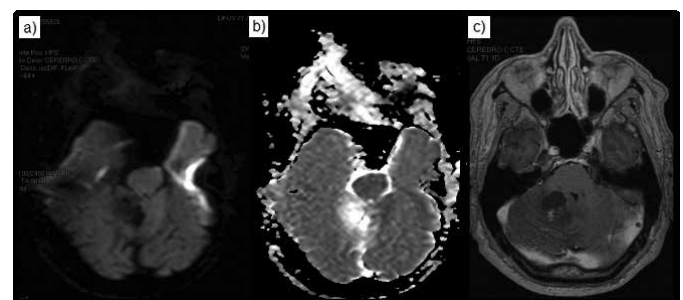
MRI of cerebellar hemangioblastoma: a) Diffusion; b) ADC; c) T1 with gadolinium.
